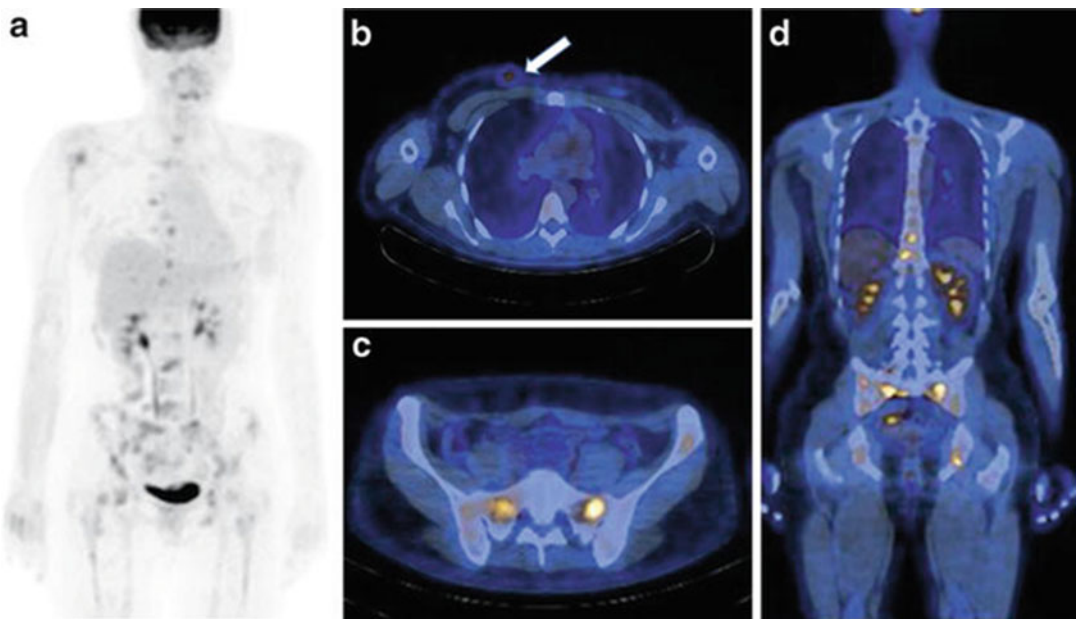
Baseline [¹⁸F]FDG PET/CT in patient with right breast cancer and metastatic bone lesions (a, MIP). Axial fused PET/CT image of [¹⁸F]FDG-avid breast nodule (b, white arrow). Diffuse bone involvement consistent with multiple focal increased metabolic activity was revealed (a, c, and d images)
